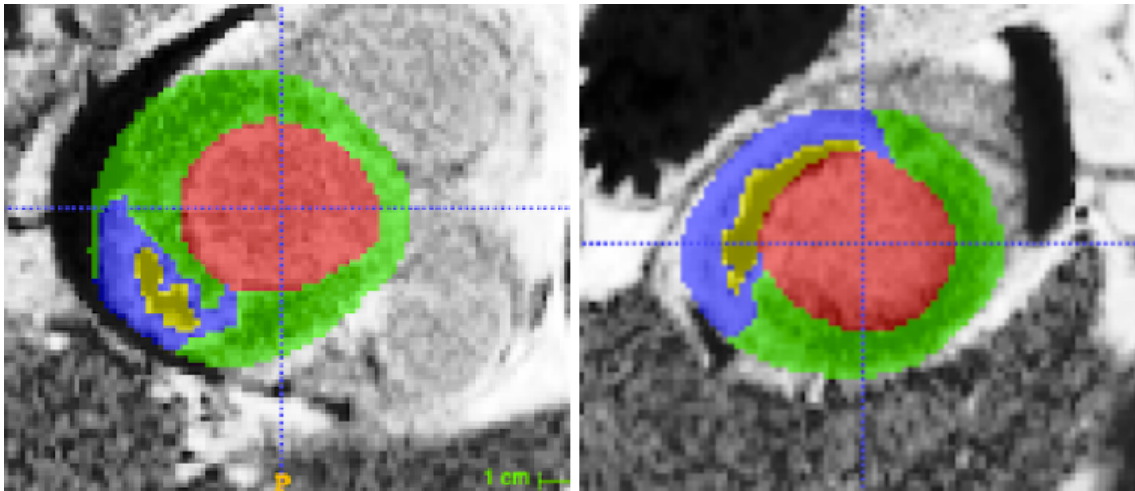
Short-axis LGE-MR images show left ventricular cavity (red), healthy MYO (green), myocardial scarring (blue), and MVO (yellow). The slices were extracted and cropped from the EMIDEC dataset (see section 4.4.5).
